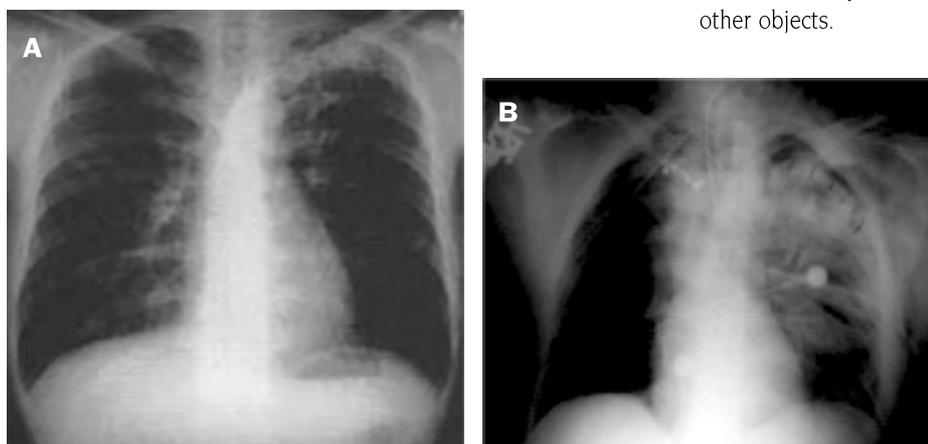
Chest X-rays depicting the gradual development of blast lung. [A] Upon admission to the emergency department. [B] Upon arrival in the intensive care unit.
